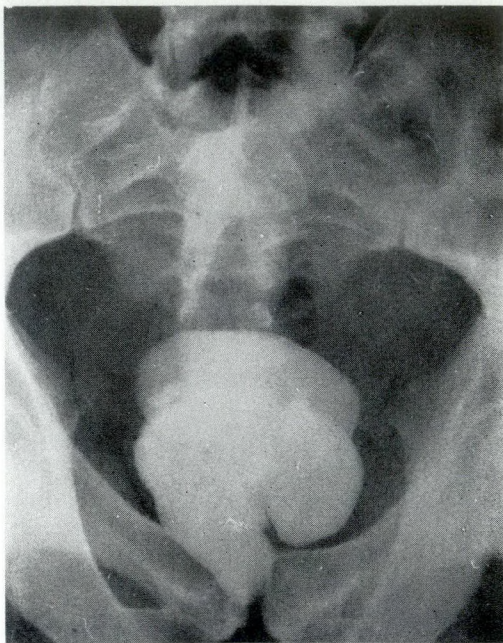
A plain radiograph of the pelvis showing the size and the position of the vesicoprostatic calculus.
